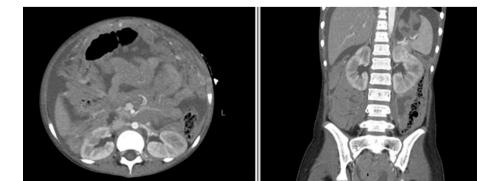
CT scan in 2014 showing gross ascites and extensive omental thickening with peritoneal nodularity. The diagnosis based on ascitic fluid analysis and omental and bone marrow biopsy along with immunochemistry and genetic analysis was Burkitt lymphoma.
